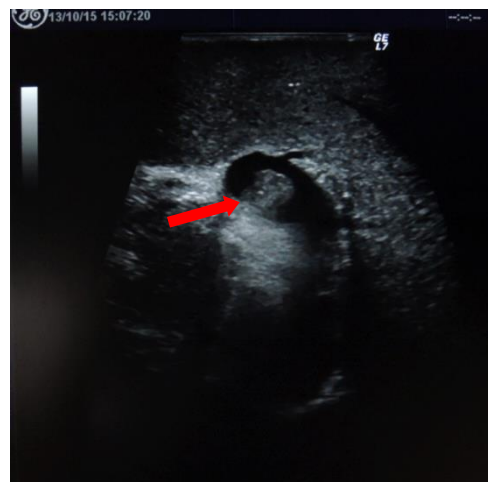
Intraoperative ultrasound imaging of inadvertent nontarget thrombus in the left branch of the portal vein following PVE (indicated by the red arrow)
